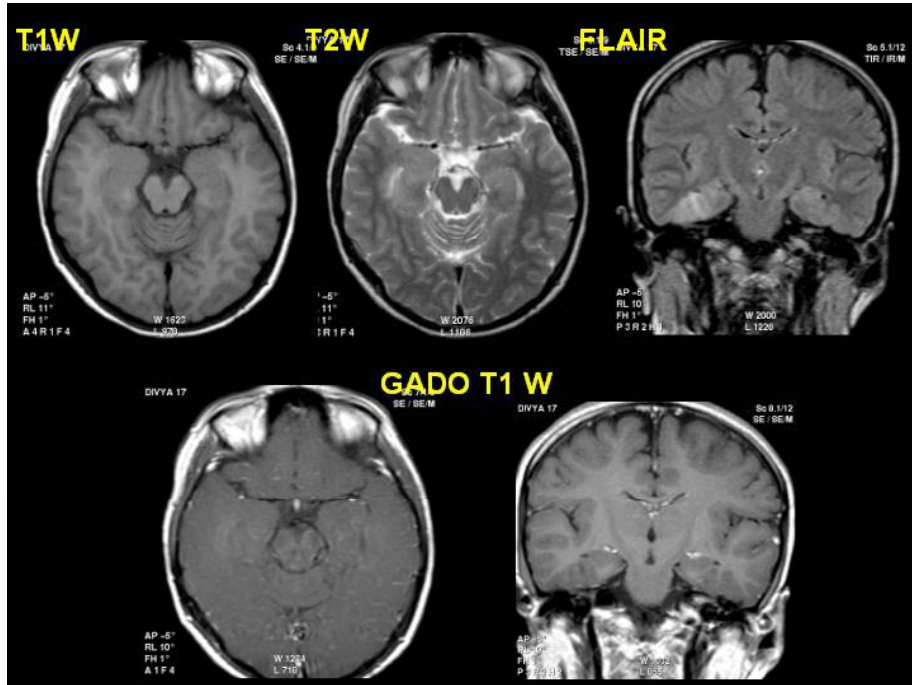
MRI shows faint, subtle, signal alteration on T2 WI in the right medial temporal cortex and non-enhancing on Post gadolinium contrast study – A nonspecific finding
